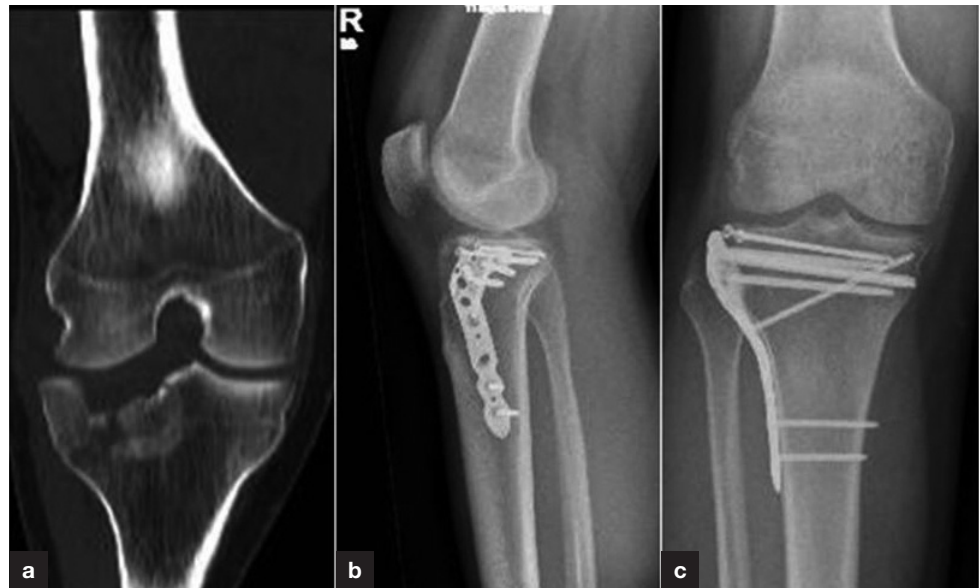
a. Preoperative anterior–posterior radiograph and (b) postoperative lateral and (c) anterior–posterior radiographs following open reduction and internal fixation of a Schatzker type III tibial plateau fracture using a pre-contoured fixed-angle locking plate and subchondral raft screws.
